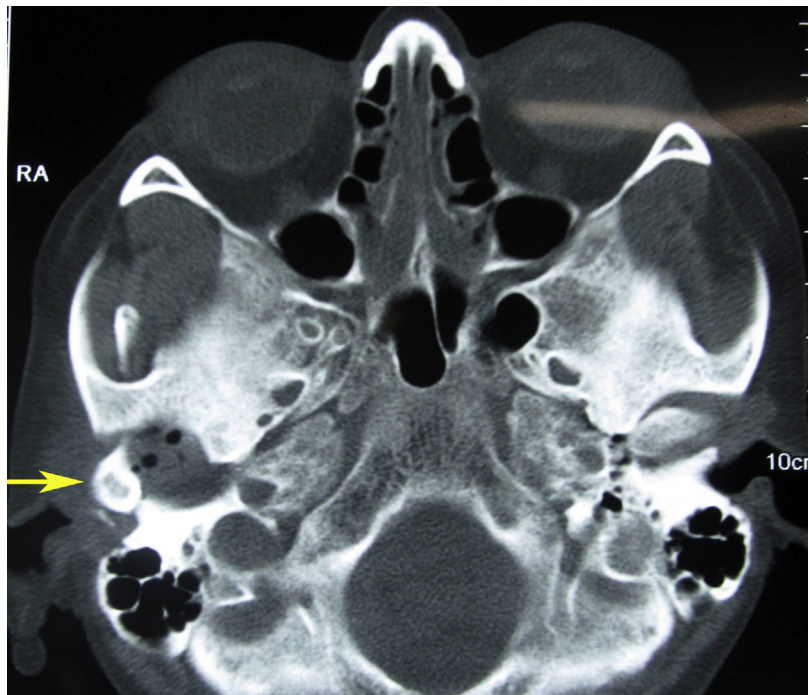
Axial section CT image showing superolateral dislocation of the right condyle (yellow arrow).
